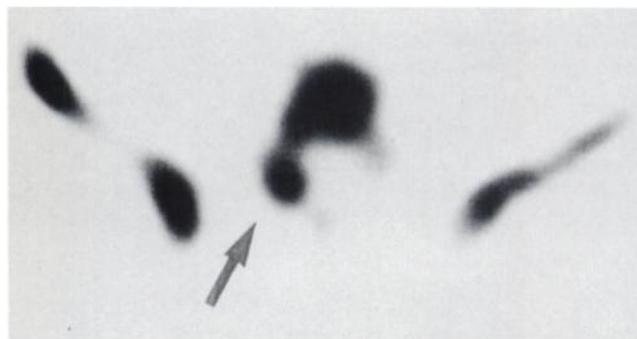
Transaxial SPECT image shows focal, increased tracer uptake in facet joint due to arthritis (arrow).
